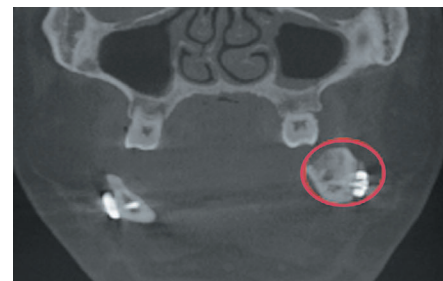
Cone beam CT information showing that a small amount of bone was left in his left mandibular molar region (red circle).
